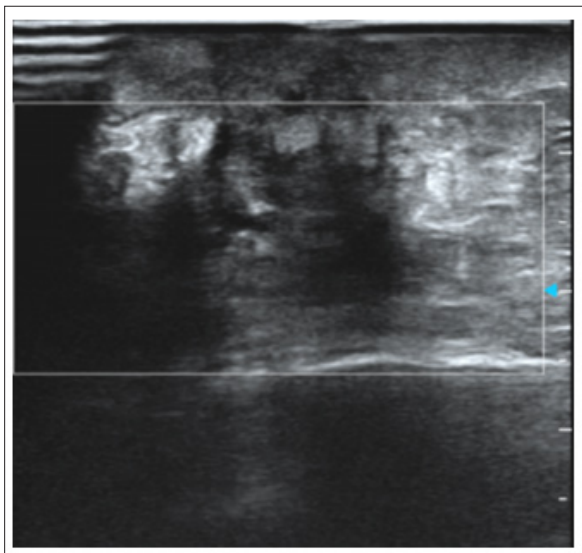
The breast ultrasound revealed a mass at the site of the mastectomy scar.
